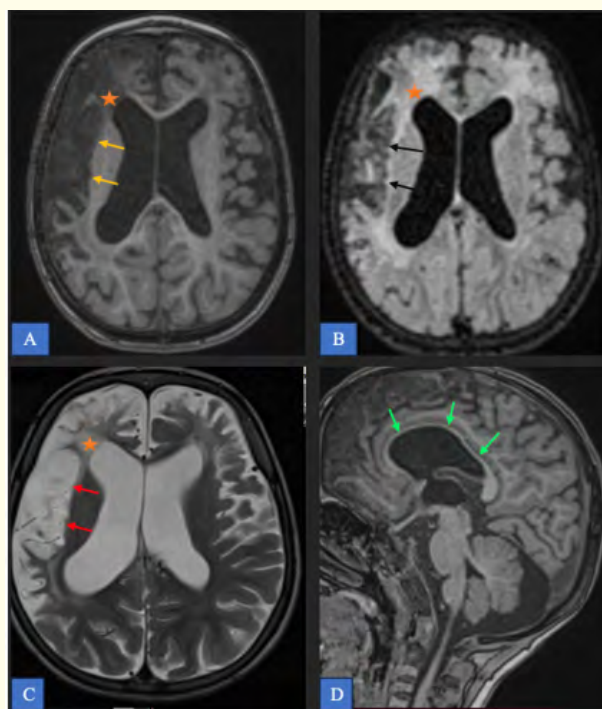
A-C: Axial T1 (A), FLAIR (B), and T2-weighted imaging (C) showing a right fronto-parieto-temporal porencephalic cyst, appearing hypointense on T1 (yellow arrows), hypointense on FLAIR (black arrows), and hyperintense on T2 (red arrows), with associated peripheral gliosis (orange asterisk) suggestive of anoxic sequelae. D: Sagittal T1 MRI slice demonstrating atrophy of the corpus callosum (green arrows) in the context of an anoxic-ischemic injury.
